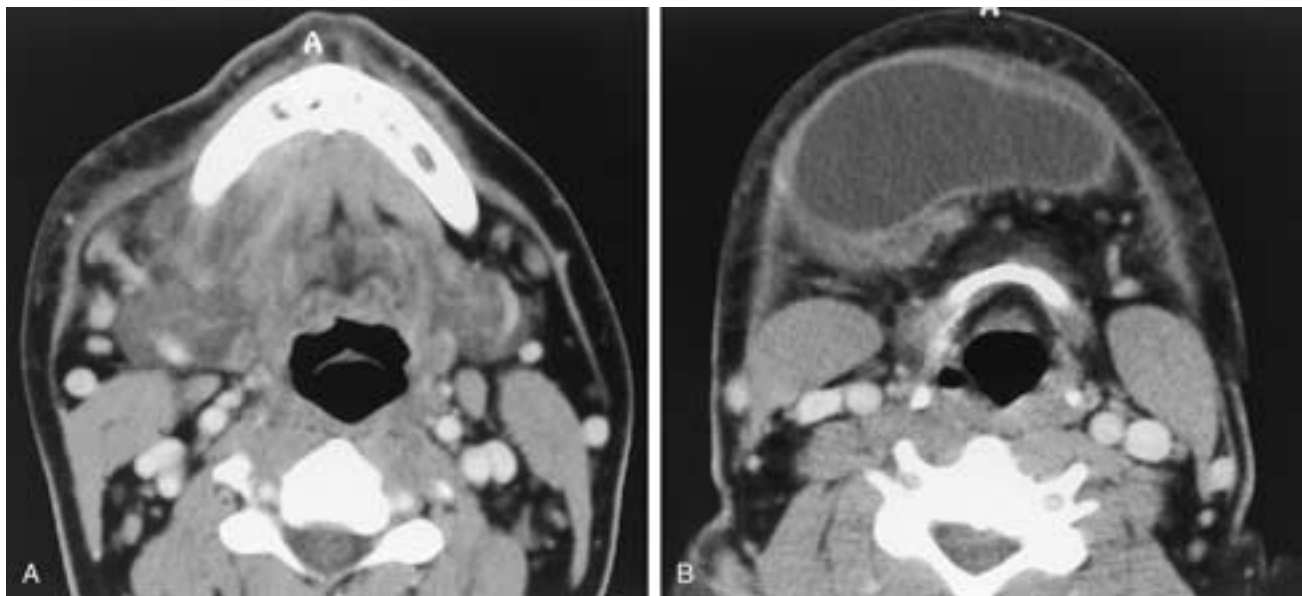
Extravasation mucocoele in a 23-year-old male with a rapidly enlarging mass under his chin. Serial contrast-enhanced CT scans (A and B) demonstrate a cystic-appearing right submandibular space mass associated with extensive changes of infection. There is marked thickening of the platysma muscle and a “dirty” stranded appearance to the subcutaneous fat. As in [Figure 27-56](#), the bulk of this extravasation mucocoele lies at the level of the hyoid bone.
